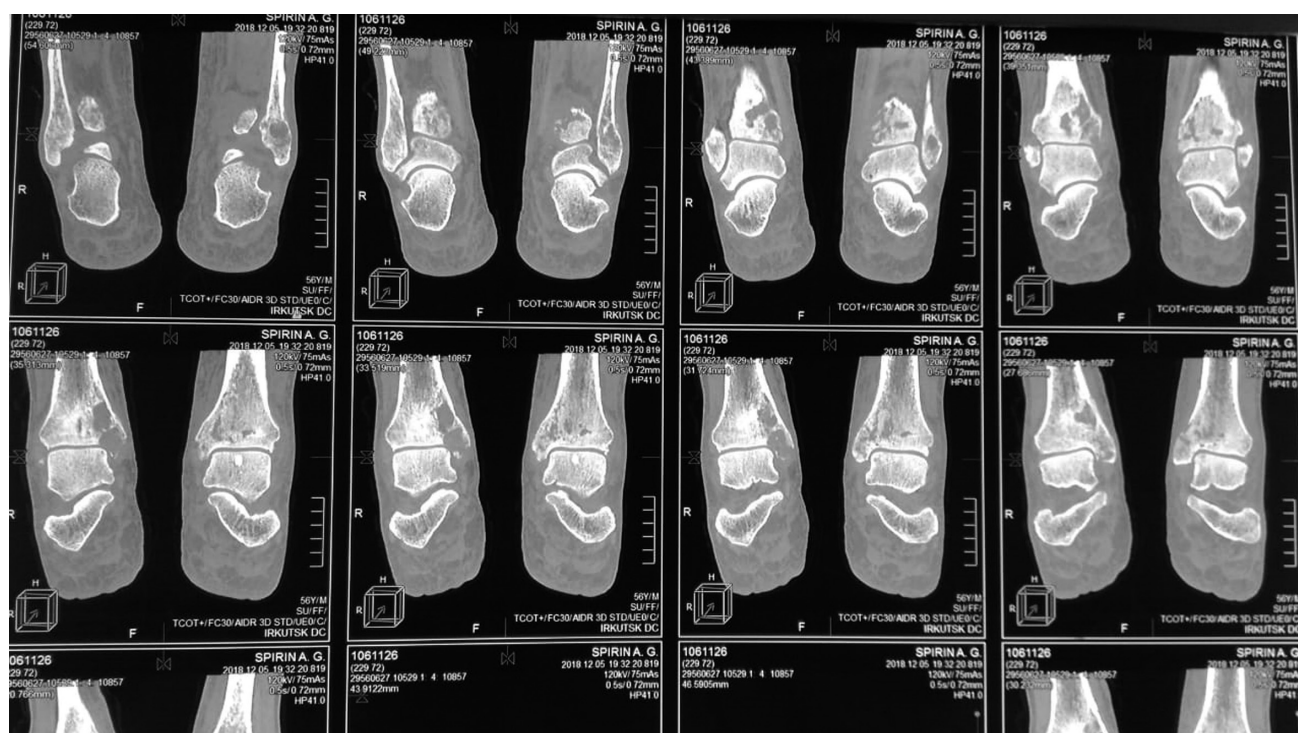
Multispiral computed tomography: osteolytic destructive changes in the distal areas of the tibial bones.
